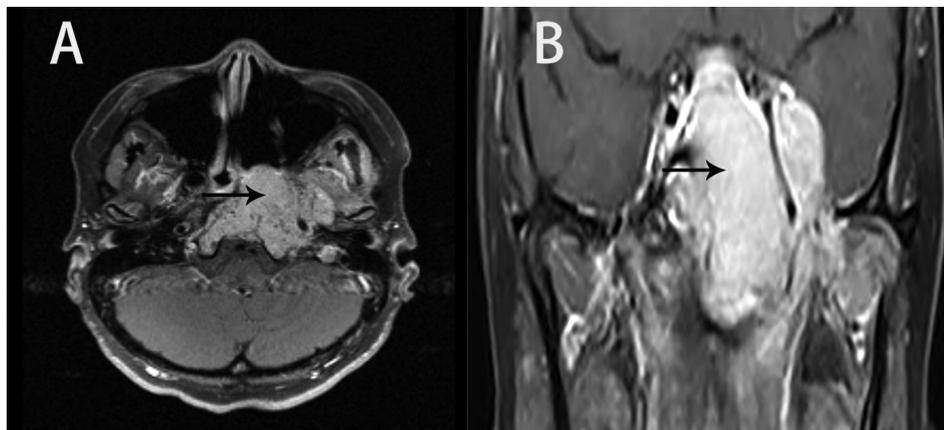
7.17 initial, contrast-enhanced MRI of adenoid cystic carcinoma extending the left pterygoid fossa, pterygoid muscle and sphenoid sinus (A) and oval foramen, cavernous sinus (B).
